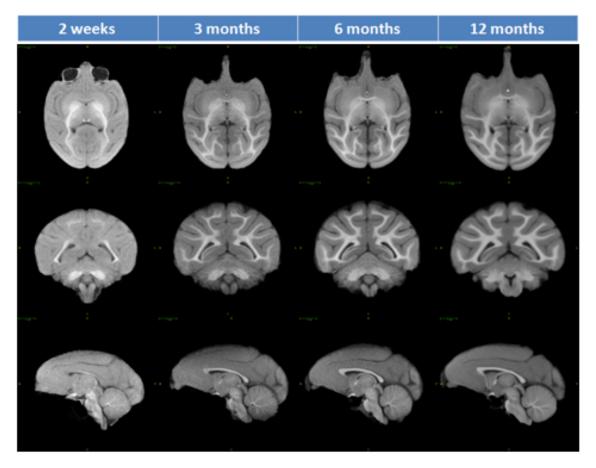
AutoSeg UNC-Emory rhesus structural MRI brain atlases. This study used the 12 months atlas as it was structurally and volumetrically most similar to the 16 month brain images examined in this project.
